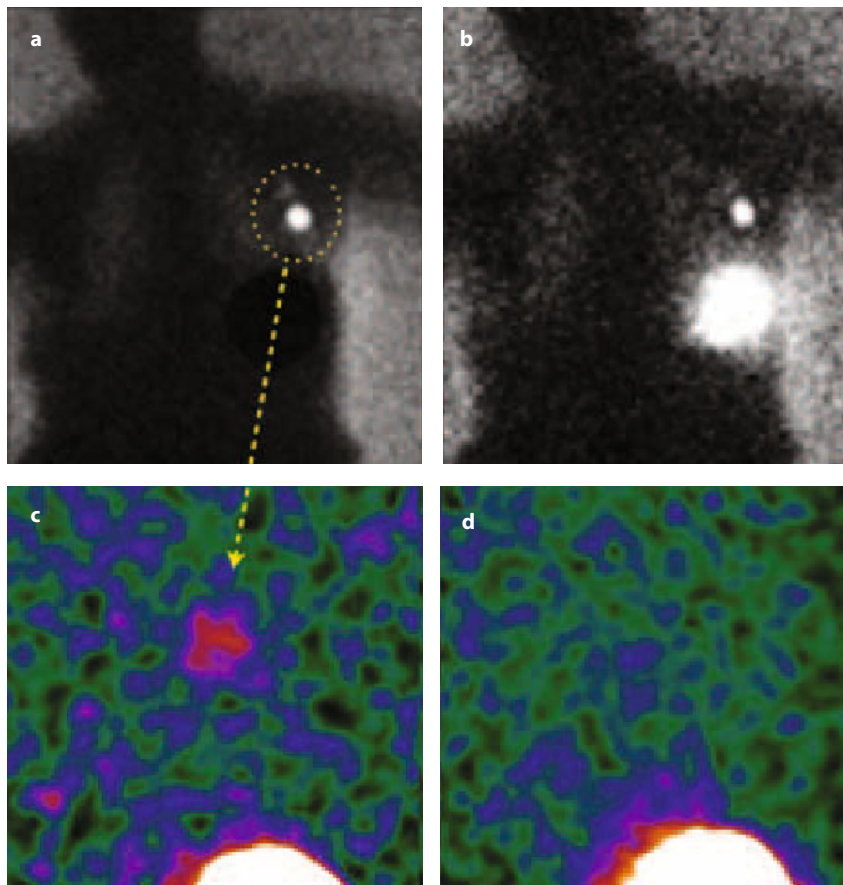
A 57-year-old patient with breast cancer in her left upper outer quadrant. a Lymphoscintigraphic image acquired with a conventional, large-field-of-view gamma camera 2 hours after intratumoral injection of 111 MBq of ^{99m}Tc -nanocolloid; at least one axillary SLN is clearly depicted (*yellow circle*). b The same image without lead shielding of the injection site shows similar radiocolloid distribution. c Operating room image obtained with a portable gamma camera prior to starting the SLN procedure, confirming similar findings (*yellow arrow*). d Image obtained with the portable gamma camera after completing radioguided SLN excision, showing no residual activity except in the intratumoral injection site. The use of the portable gamma camera, in addition to the hand-held, nonimaging gamma probe, was especially useful to confirm the completeness of SLN removal
